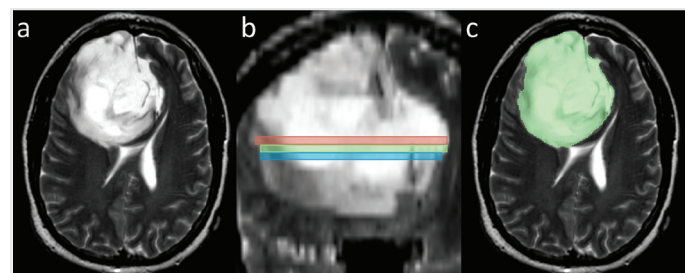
Segmentation style in a 47-year-old male with a grade III diffuse glioma. (a) T2-weighted axial slice shows the right-sided frontal tumor with extension to the left side. (b) Reconstructed coronal T2-weighted MRI image presents the segmentation data decomposed to three consecutive slices. Two axial slices including middle (green-colored segmentation) and upper (red-colored segmentation) or lower (blue-colored segmentation) ones were included in this study. (c) Axial T2-weighted image shows one of the two selected segmentations
